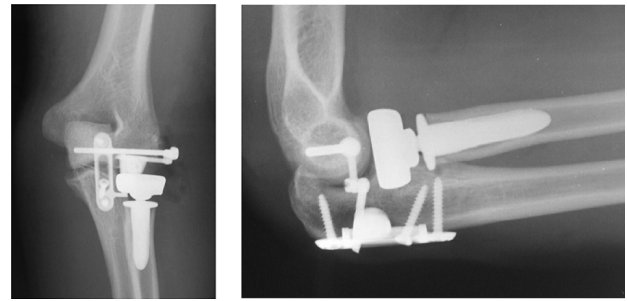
Anteroposterior and lateral radiograph of the patient after stabilization surgery with the internal joint stabilizer of the elbow.
